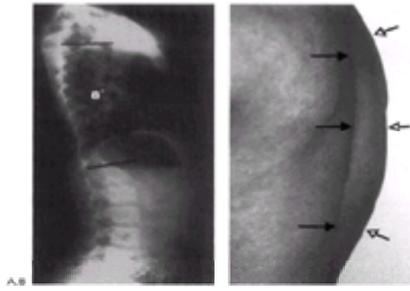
A: This standing lateral radiograph demonstrates the decreased kyphosis of the thoracic spine (“hypokyphosis”), commonly seen in thoracic curves in patients with idiopathic scoliosis common in adolescent idiopathic scoliosis. B: An oblique view clinical photograph of the patient demonstrates both the prominence of the rib cage due to the rotational deformity (*open arrows*), as well as the flattening of the thoracic kyphosis along the midline (*closed arrows*).
